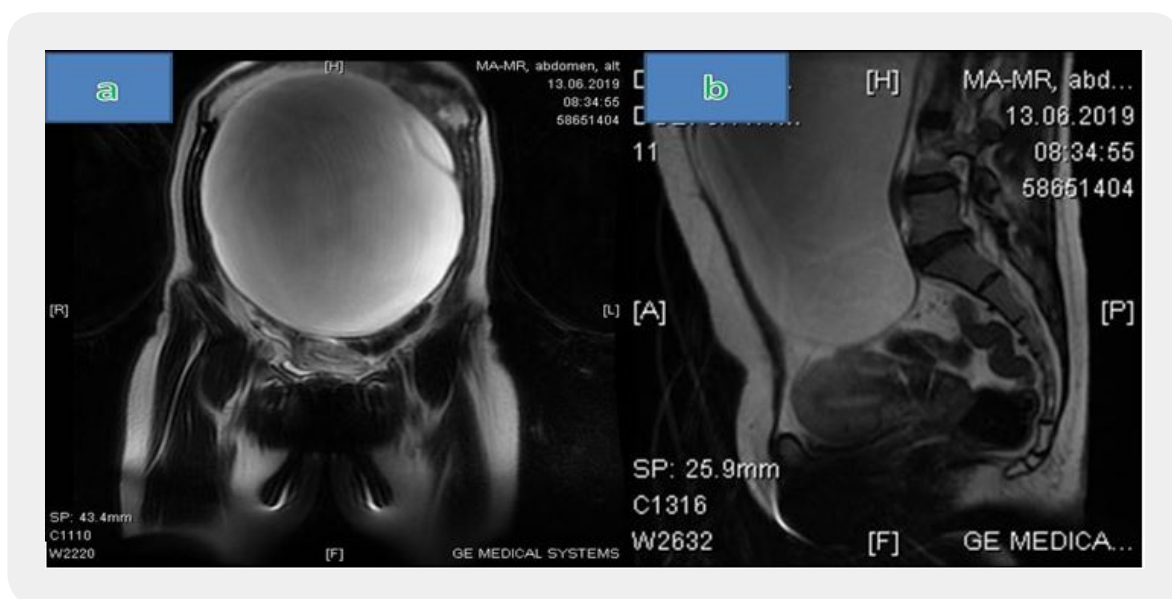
MR image of giant pelvic mass
